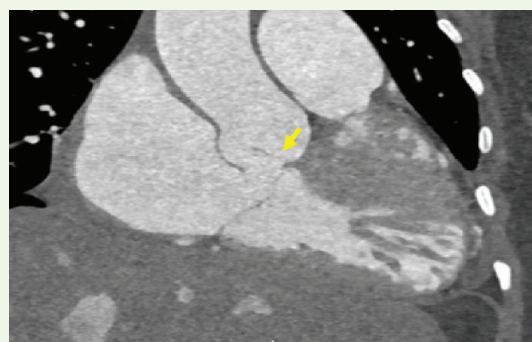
Coronal multiplanar reformatted CT image demonstrating the fistulous tract extending from the non-coronary sinus into the right atrium (arrow).
